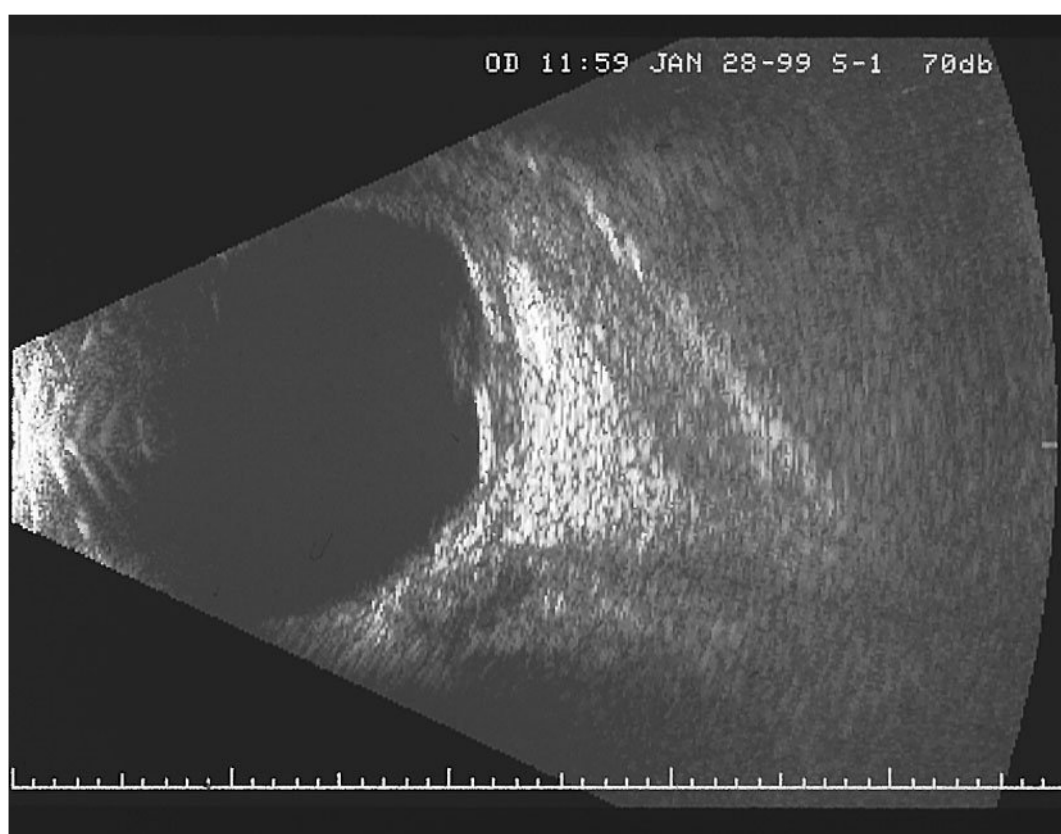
A B-scan ultrasound at 6 years' follow-up revealed a significant decrease in tumor height with resolution of the overlying retinal detachment.
